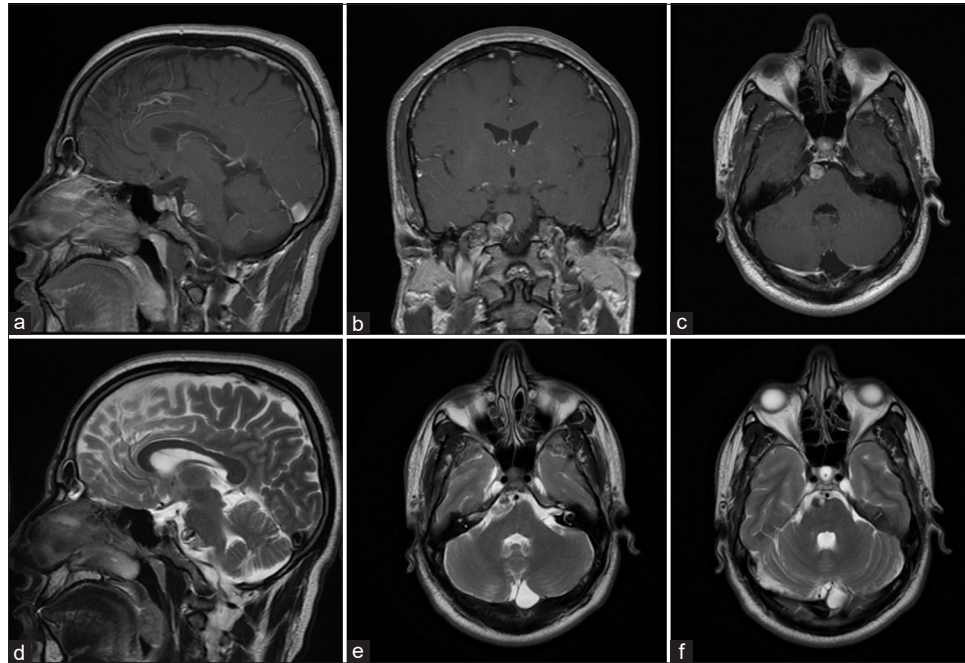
Preoperative MRI images. (a) Sagittal T1-weighted contrast-enhanced image; (b) coronal T1-weighted contrast-enhanced image; (c) axial T1-weighted contrast-enhanced image; (d) Sagittal FSE T2-weighted image; (e) axial T2-weighted sequence; and (f) axial T2-weighted sequence.
